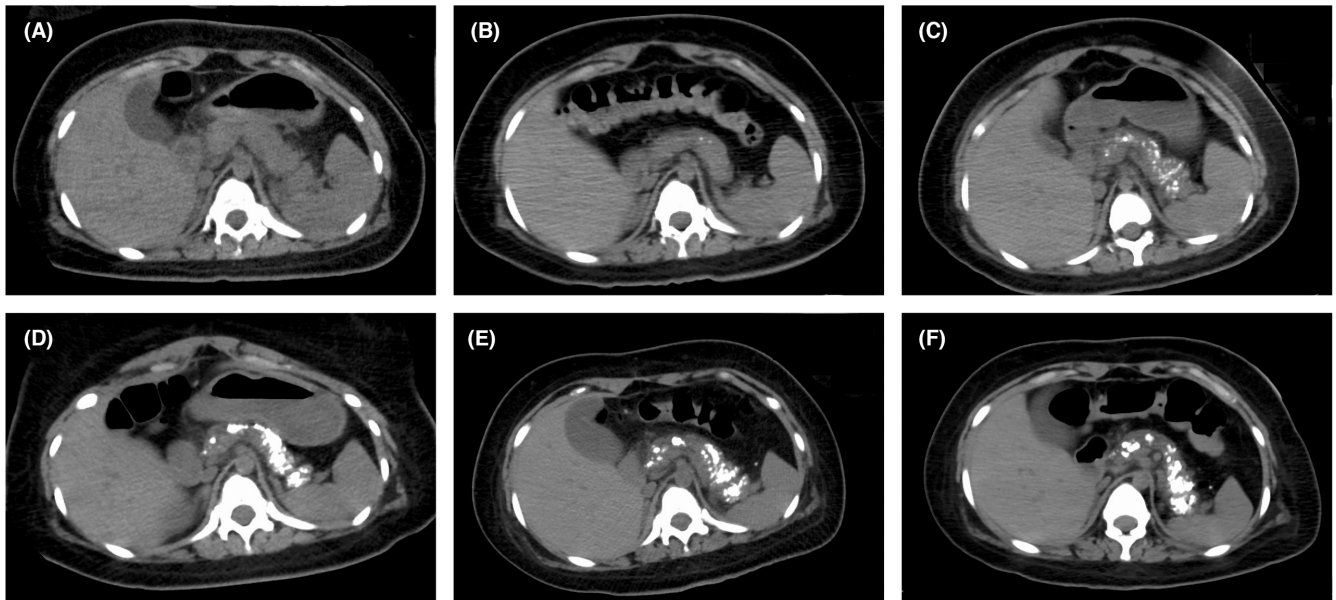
Abdominal computed tomography (CT) findings. The first CT finding (A) showed pancreatic swelling, which is the first indication of acute pancreatitis. After 1 year, pancreatic stones appeared in the pancreatic duct (B), and 2 years later, diffuse pancreatic stones distributed throughout the pancreas and mild atrophic pancreas were observed, resulting in chronic pancreatitis (C). In the third year, the number of pancreatic stones increased (D), resulting in pancreatic atrophy progression (E, F).
